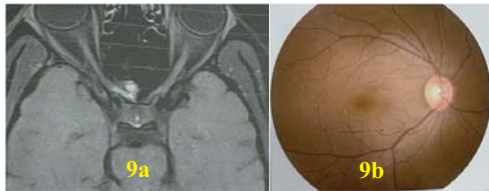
T1 weighted image of the MRI shows high intensity at distal part of the right optic nerve and adjacent ethmoid air cells. CSF intensity is not seen around the optic nerve. The MRI features suggestive of contusion of the right optic nerve along with tear of overlying dura matter due to fracture of right posterior ethmoid air cells. The CFP of the right eye shows normal appearance at presentation.
